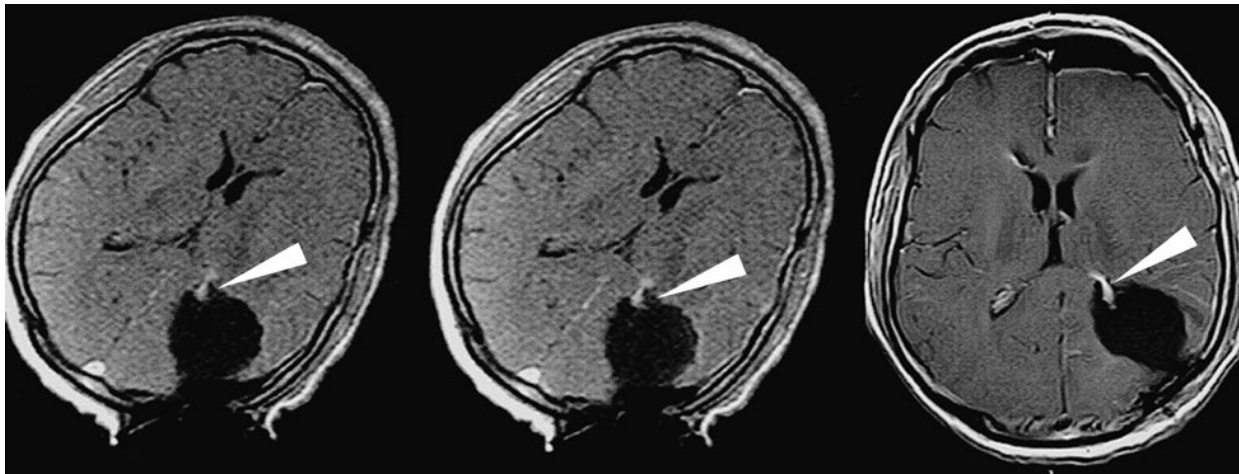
Surgically induced, increased enhancement of the choroid plexus. Note that the ventricle has been opened. Intraoperative T1-weighted images (*left*, 5 minutes postcontrast; *middle*, 20 minutes postcontrast) (532/15/3) show increased enhancement of the left choroid plexus (*arrows*) that remains constant during the observed time interval. Early postoperative MR image (*right*) (674/20/2) shows the persistence of this enhancement (*arrow*).
